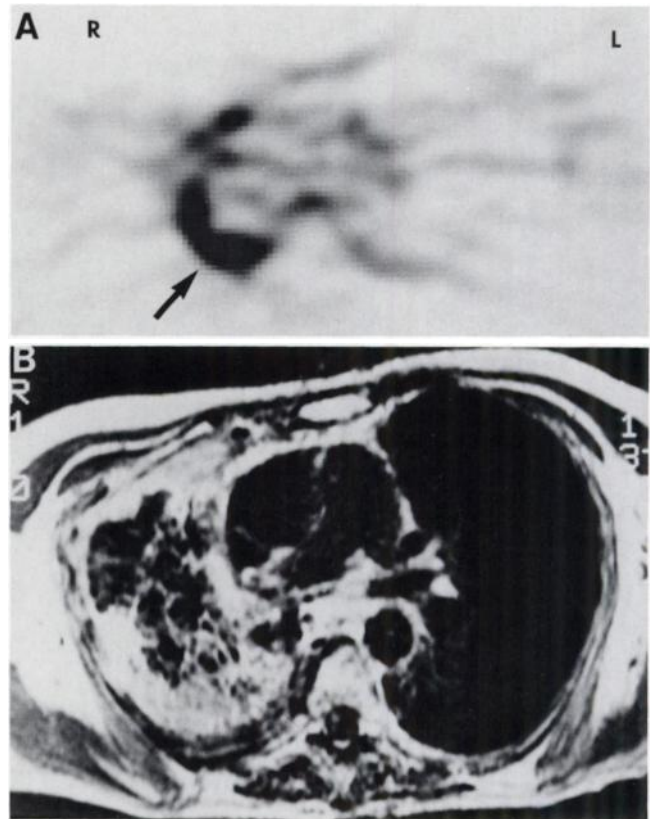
False-positive PET diagnosis in Patient 6, a 50-yr-old woman with adenocarcinoma. (A) Transaxial PET image of the chest shows markedly increased FDG uptake (arrow) along the right chest wall in a curvilinear shape. (B) MRI at the same level shows a mass around the right chest wall with bronchiectasis and atelectasis.
